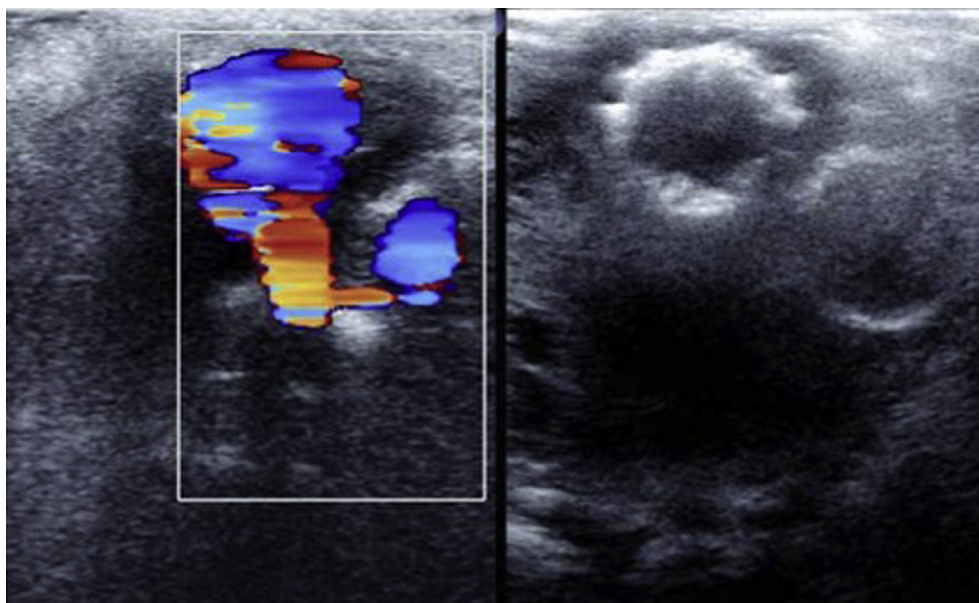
Intraoperative duplex ultrasound: transverse view overlying right sided common iliac artery distal fixation site (linear 7–4 MHz transducer placed directly onto the anterior aortic surface). The right lateral aspect of the sac shows active, bi-directional flow just posterior to the right limb. In the distal margin of the sac there is a 5 mm posterior lumbar vessel with flow entering the aortic sac. Following further dissection and ligation of this lumbar vessel, successful exclusion of flow from the sac with thrombosis of the previously active flow cavities and absence of the previously seen lumbar vessel.
